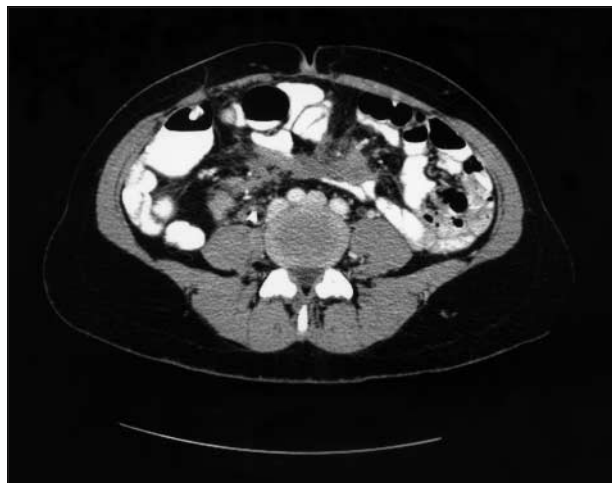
Computed tomographic view of a desmoid tumor infiltrating the mesenteric root.
